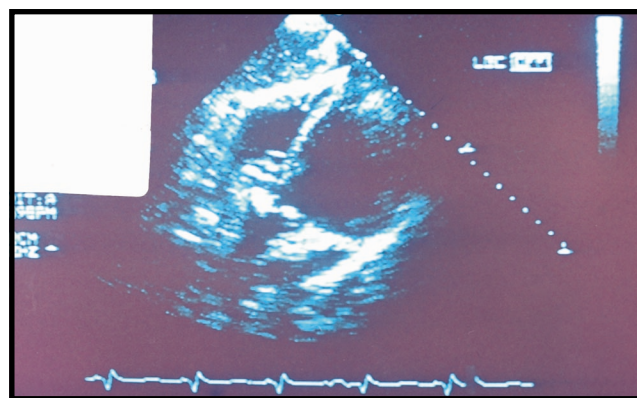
Transthoracic echocardiogram apical view showing vegetation on aortic valve.
